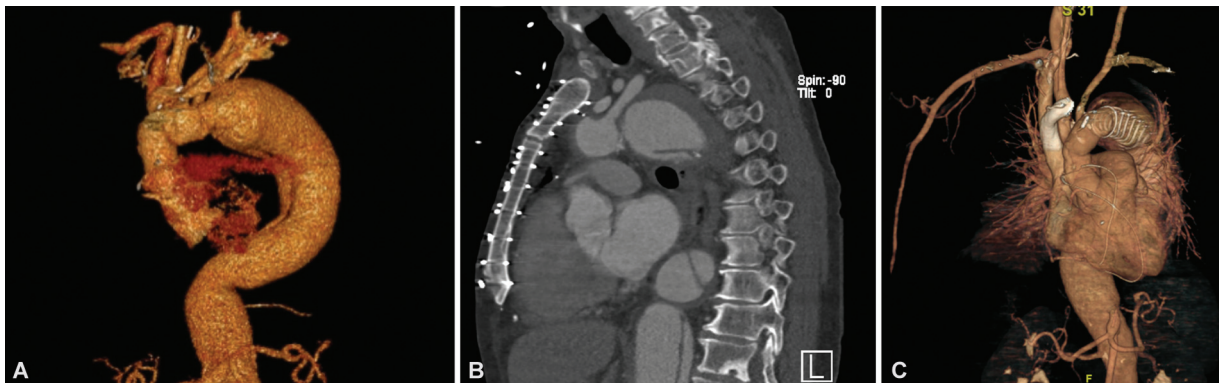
Computed tomography (CT) scan of a patient who underwent a prior repair of a DeBakey I dissection with a “classic” zone 3 arch replacement (A). The residually dissected aorta grew in size, requiring repair. However, no landing zone was left behind, as the LSA is adjacent to the aneurysm (B), and all head vessels sit directly adjacent to one another. The patient thus required carotid-subclavian transposition, followed by redo zone 2 arch replacement and FET, with debranching of the IA and LCCA proximally on the arch (C). This is in preparation for a future open thoracoabdominal aneurysm repair. IA, innominate artery; FET, frozen elephant trunk; LCCA, left common carotid artery; LSA, left subclavian artery.
